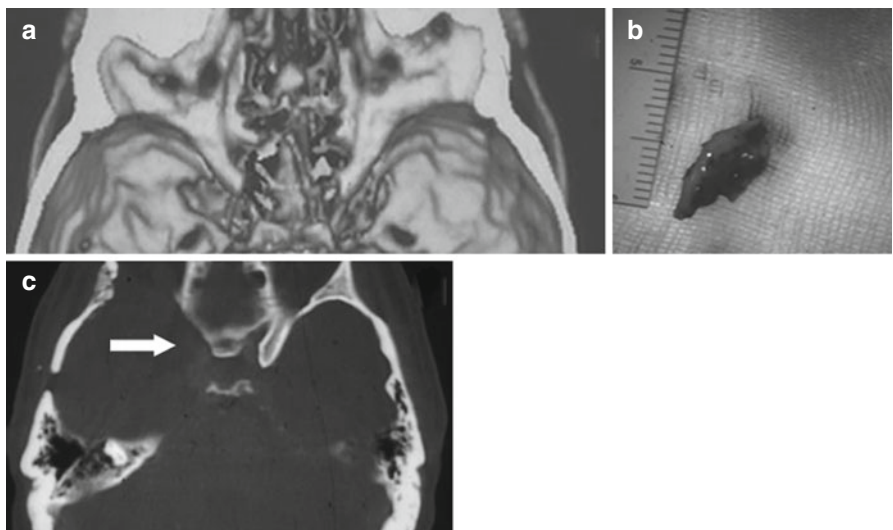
(a) 3D CT scan. (b) Anterior clinoid process extracted in one piece through extradural approach. (c) CT scan with bone windows (axial section) showing anterior clinoidectomy associated to unroofing of optic canal (arrow)
